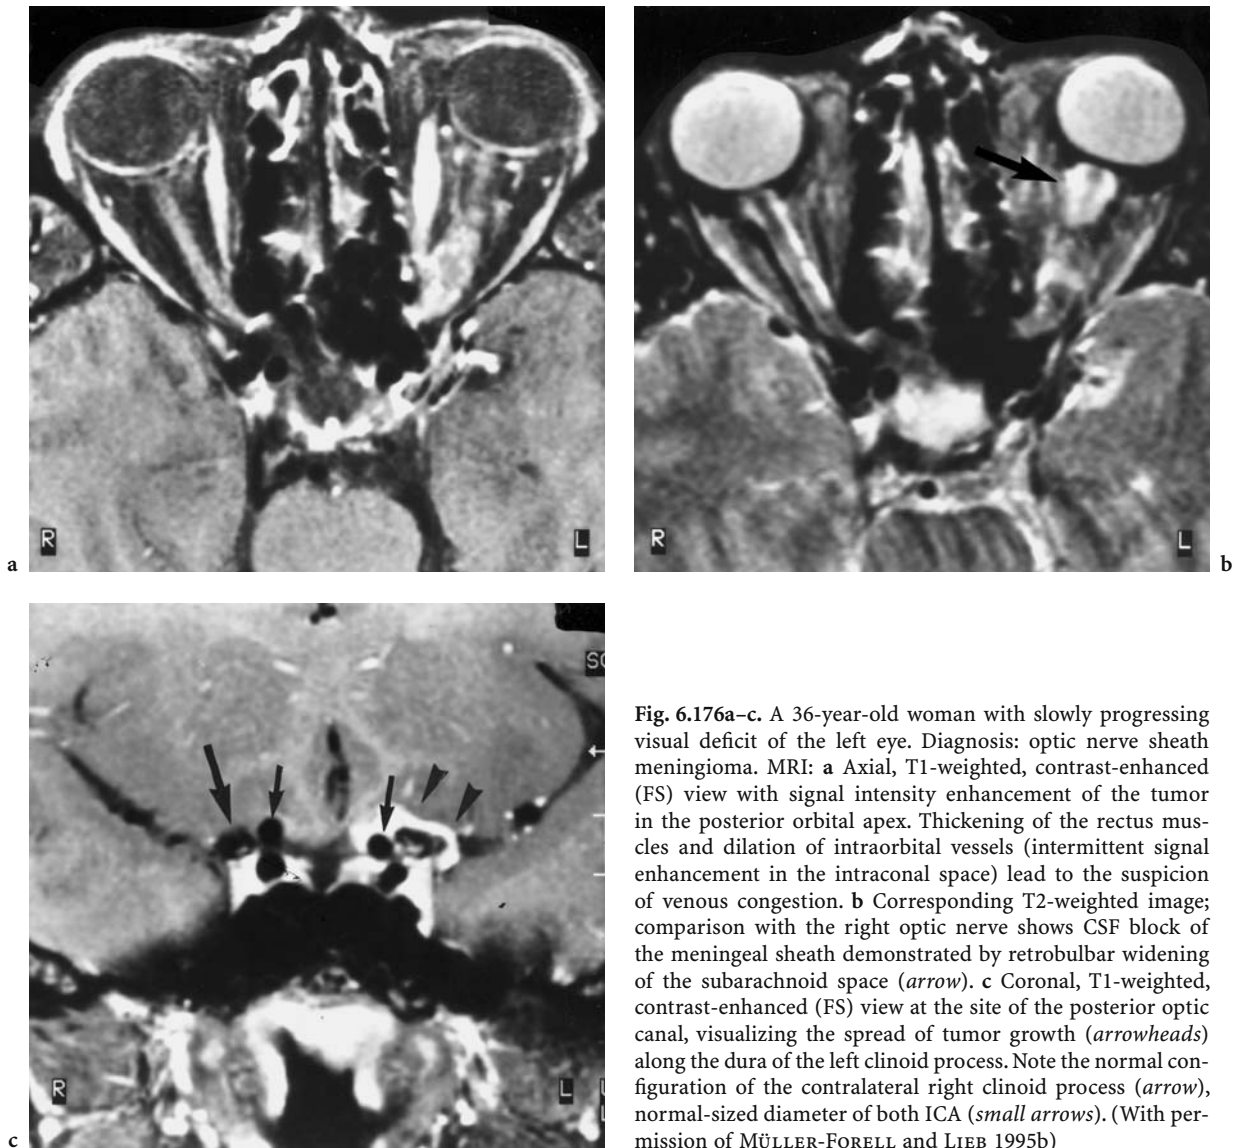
A 36-year-old woman with slowly progressing visual deficit of the left eye. Diagnosis: optic nerve sheath meningioma. MRI: a Axial, T1-weighted, contrast-enhanced (FS) view with signal intensity enhancement of the tumor in the posterior orbital apex. Thickening of the rectus muscles and dilation of intraorbital vessels (intermittent signal enhancement in the intraconal space) lead to the suspicion of venous congestion. b Corresponding T2-weighted image; comparison with the right optic nerve shows CSF block of the meningeal sheath demonstrated by retrobulbar widening of the subarachnoid space (*arrow*). c Coronal, T1-weighted, contrast-enhanced (FS) view at the site of the posterior optic canal, visualizing the spread of tumor growth (*arrowheads*) along the dura of the left clinoid process. Note the normal configuration of the contralateral right clinoid process (*arrow*), normal-sized diameter of both ICA (*small arrows*). (With permission of MÜLLER-FORELL and LIEB 1995b)
